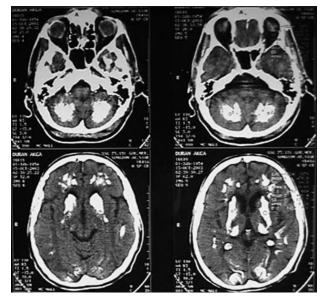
Cranial CT scan revealing bilateral basal ganglia calcifications.
